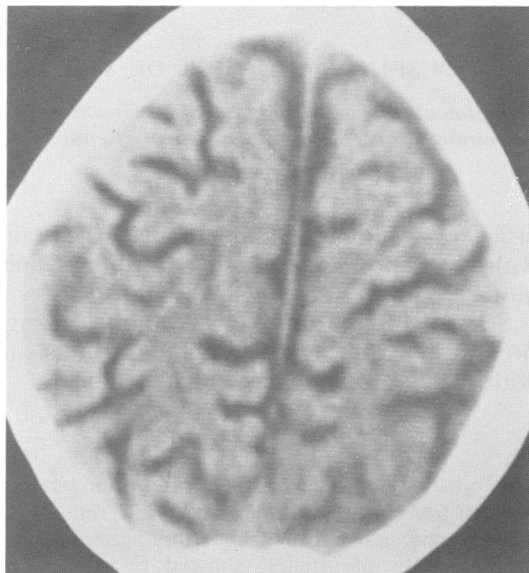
Computed tomogram of case 3, showing wide cerebral sulci.*
